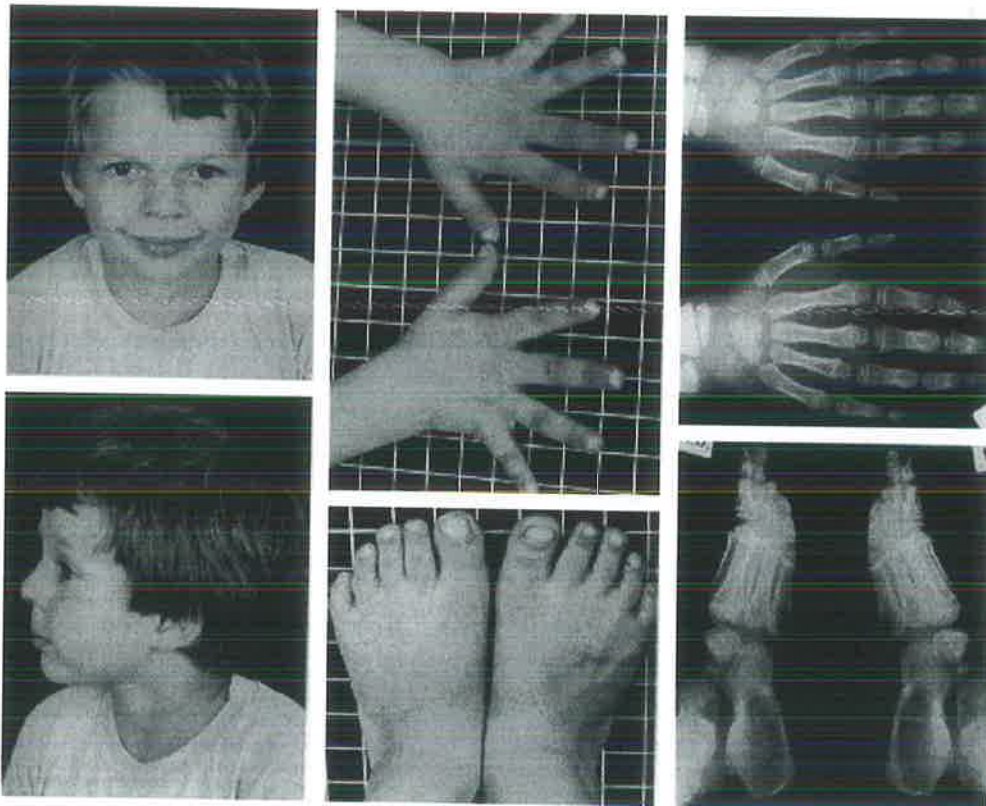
Clinical photographs and radiographs of IV-19. There are minimal craniofacial features but multiple radiologic abnormalities. In the hands these include coned epiphyses involving the middle phalanges of the index and fifth fingers bilaterally, associated shortness of the adjacent phalanges with premature fusion at the site of the coned epiphyses, and congenital fusion of the capitate and hamate. In the feet, abnormalities include coned epiphyses involving the proximal phalanges of the 2nd, 3rd, 4th, and 5th toes bilaterally, distal phalangeal hypoplasia of the 2nd toes, enlarged epiphyses at the base of the distal phalanx of the 3rd and 4th toes, and calcaneocuboid fusion.
